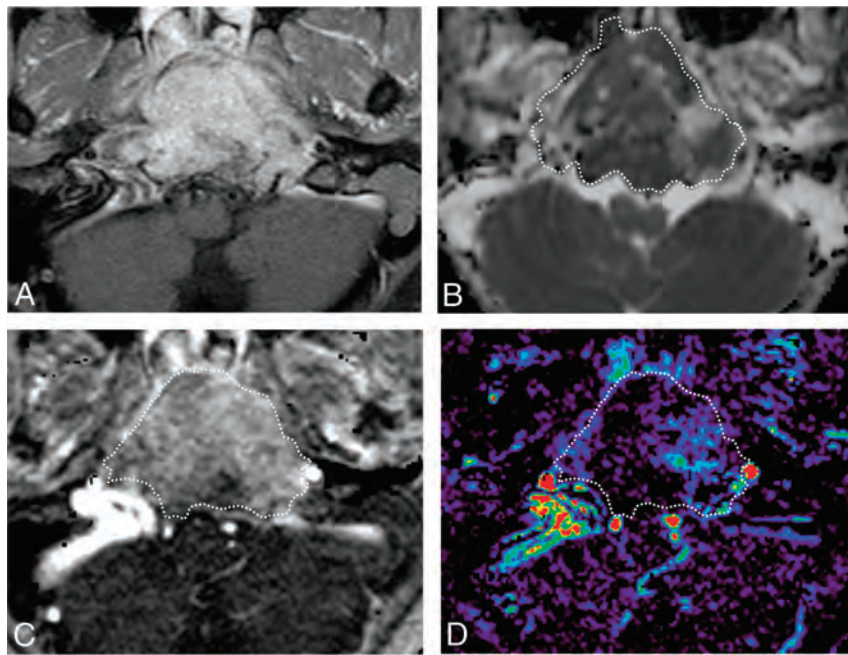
A 16-year-old boy with a chordoma in the clivus. *A*, Axial fat-saturated postcontrast T1-weighted image shows a heterogeneously enhancing mass in the clivus. *B*, An ROI was placed on the ADC map, and the nADCmean was 1.5. *C*, An ROI was placed on the permeability map, and V_p , K^{trans} , and V_e were calculated. *D*, V_p is 0.08.
